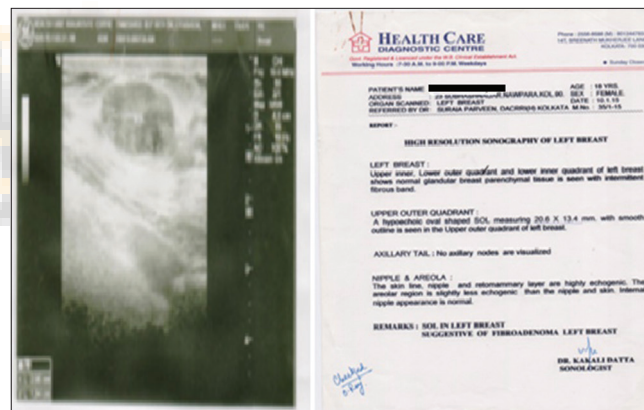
Ultrasonography report of the left breast on January 10, 2015 (during treatment)
